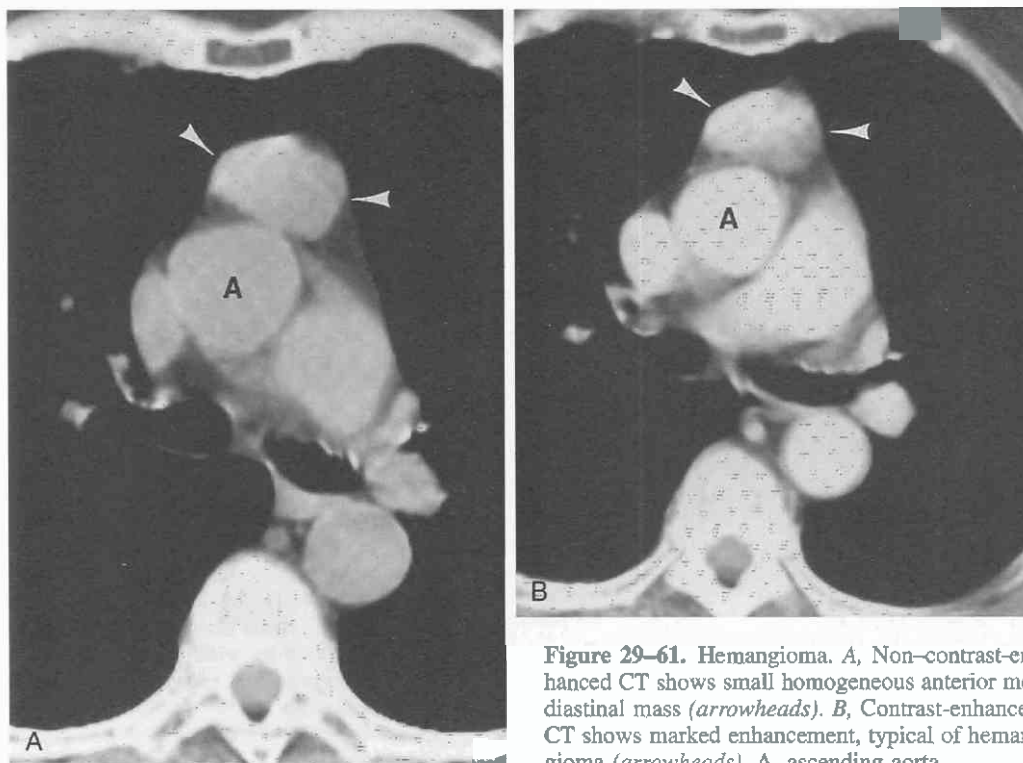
Hemangioma. A, Non-contrast-enhanced CT shows small homogeneous anterior mediastinal mass (arrowheads). B, Contrast-enhanced CT shows marked enhancement, typical of hemangioma (arrowheads). A, ascending aorta.
